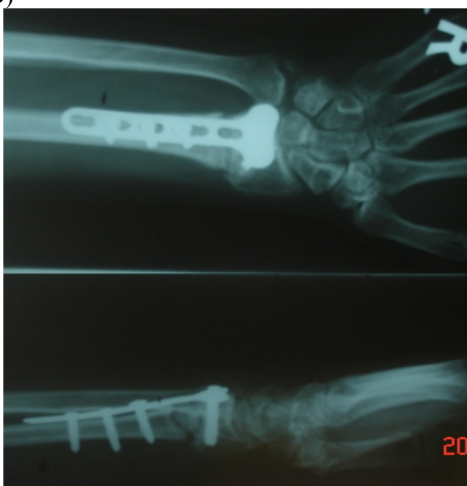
and 2 B. The patient's; preoperative comparative, Radiographs (A) and postoperative radiographs (B).
